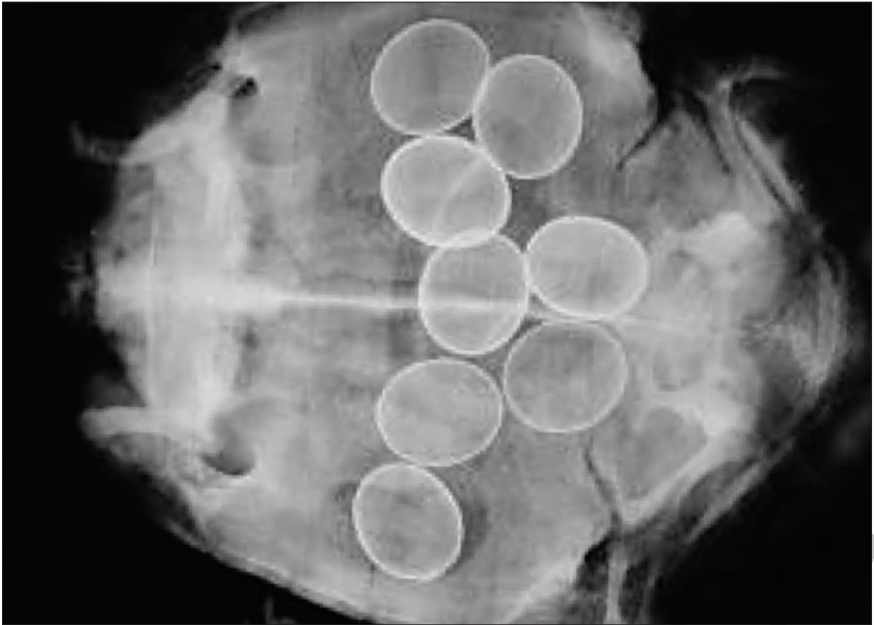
X-ray plate of a tortoise carrying calcified eggs.
